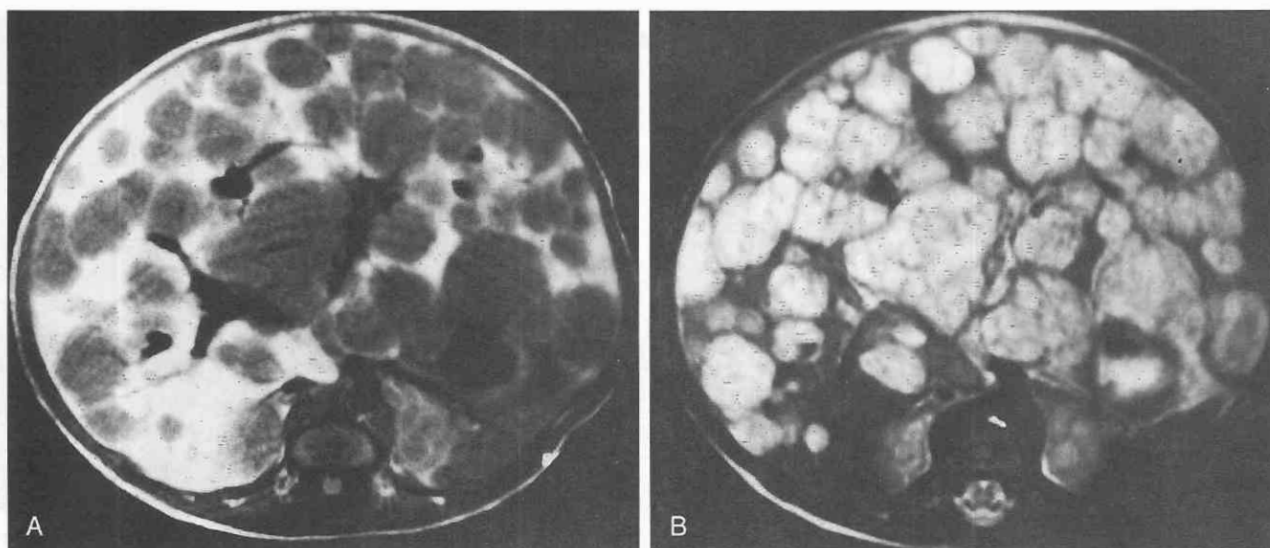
Hemangioendothelioma. A, T1-weighted MR image in an infant with multifocal hemangioendothelioma in the liver. Numerous hypointense foci are seen throughout the liver. B, On a T2-weighted MR image, these same foci are hyperintense.
